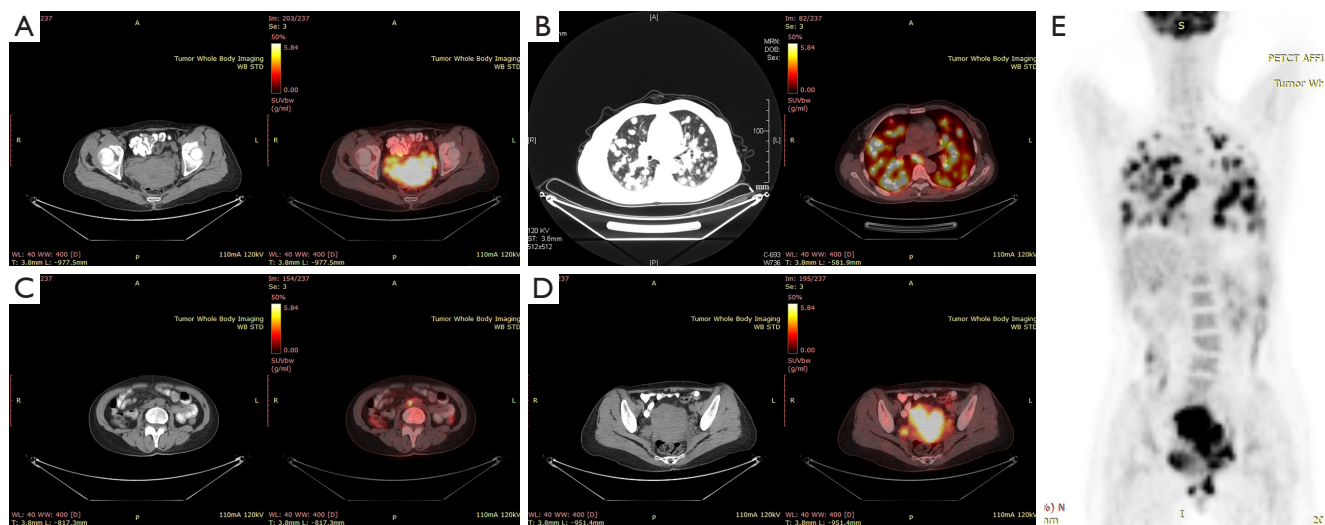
PET-CT result of the patient. Hypermetabolic foci in the cervix, vagina, iliac vessels, para-aortic lymph nodes, and lung. (A) Primary foci in the cervix; (B) multiple metastases in the lung; (C) para-aortic hypermetabolic lymph nodes; (D) para-iliac vessels hypermetabolic lymph nodes and uterine cavity invasion; (E) the patient's whole body hypermetabolic distribution. PET-CT, positron emission tomography-computed tomography.
